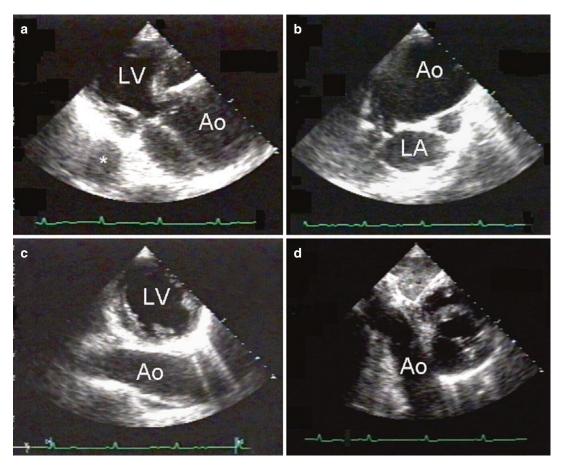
Transthoracic imaging in a patient with an ascending aortic aneurysm and dilated descending aorta. (a) modified left parasternal longitudinal view of the ascending aorta (transverse view of the descending aorta
